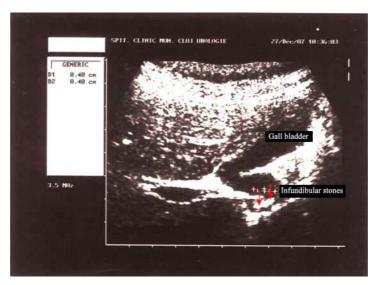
The ultrasonographic image of the folded gall bladder with the stones of 4 mm each in the bladder infundibulum.
